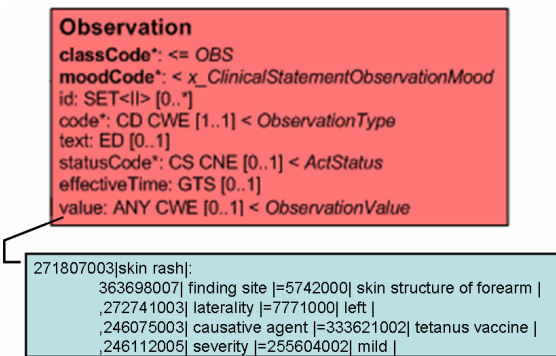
Using a SNOMED CT expression<sup>18</sup> to represent the finding directly in HL7v3
